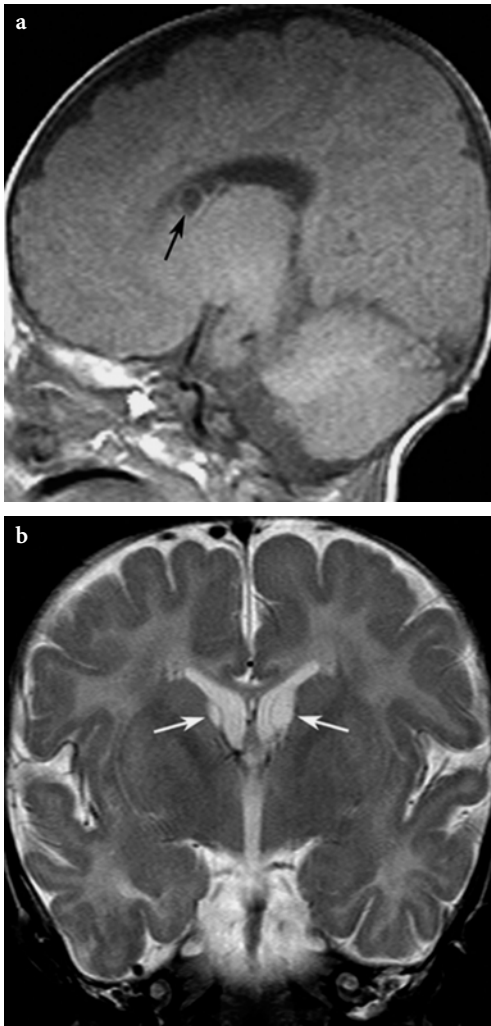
Germinolytic cysts in Zellweger disease. a Sagittal T1-weighted spin-echo image in a 10-month-old male patient. b, c. Coronal T2-weighted fast-spin-echo (b) and gradient-echo image (c) in a 6-month-old female patient. Subependymal germinolytic cysts (*arrows*) are present along the lateral walls of frontal horns on both sides. These are easier to depict on gradient echo image in this case, but the best imaging modality is FLAIR technique (see Fig. 13.52)
